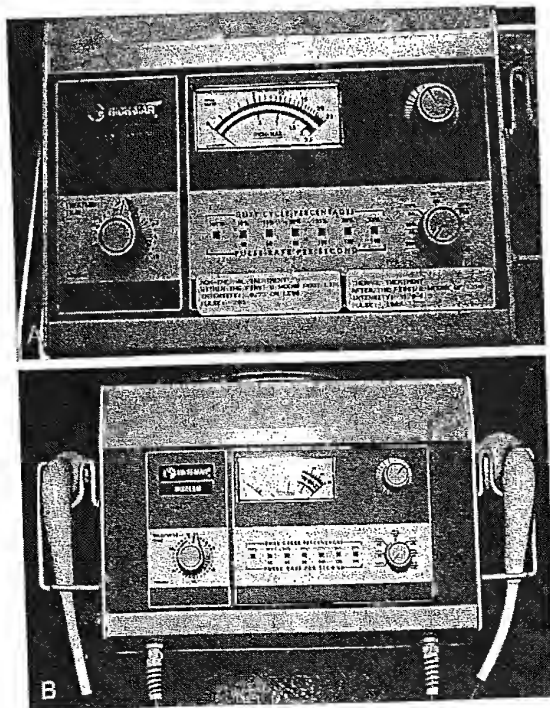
A, One- and B, three-watt ultrasonic generators that can be used for preoperative or postoperative liposuction.
